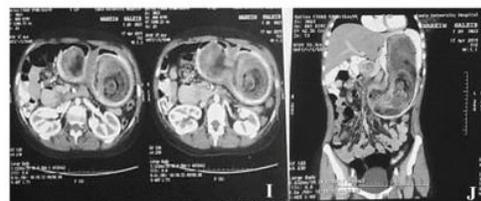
(I & J): CT finding; Case 4
